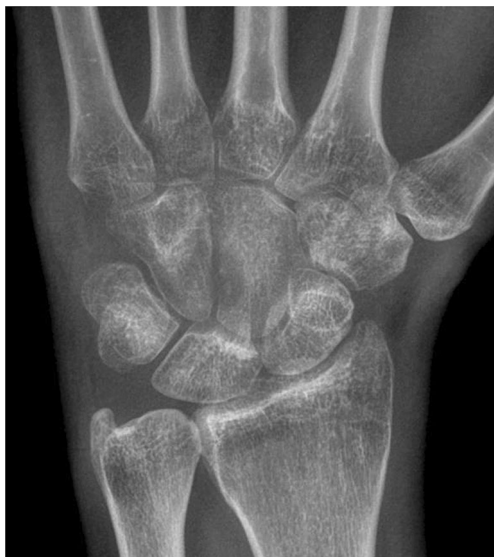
Anteroposterior radiograph of the left wrist
